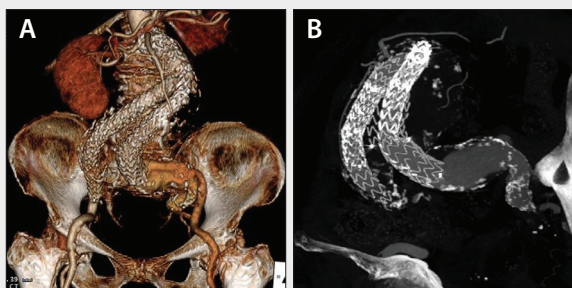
CT scan revealed CIA dilatation (A) with a type Ib endoleak and aneurysm sac expansion (B).
